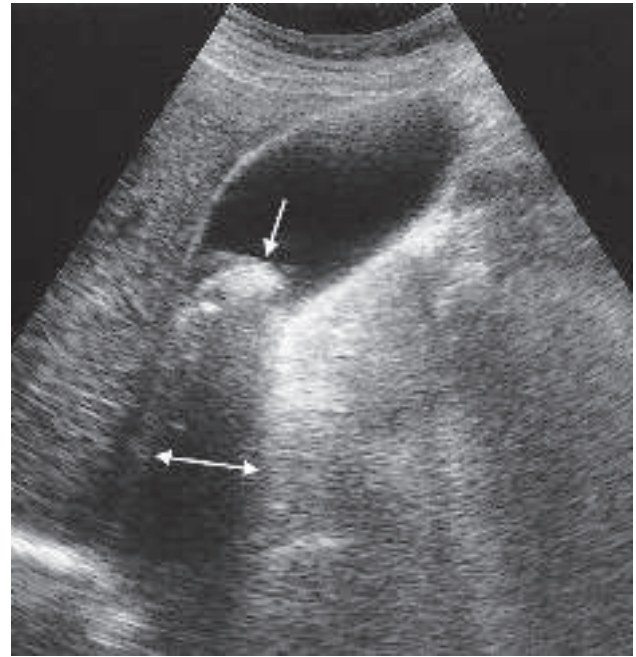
Ultrasound scan of gall bladder showing a large stone in the neck of the gall bladder (downward pointing arrow). Note the acoustic shadow behind the stone (horizontal double-headed arrow).
